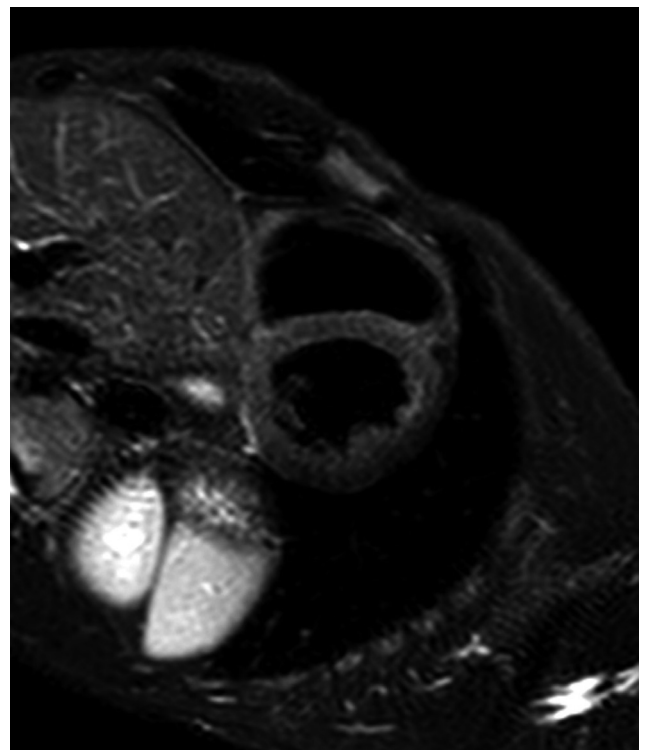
Cardiac magnetic resonance, T2-weighted sequences depicting absence of extracellular edema
